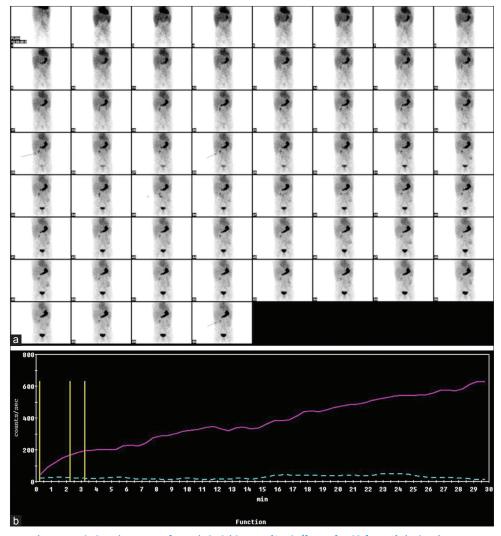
(a) Tc-99m pertechnetate scintigraphy was performed. Serial images (1 min/frame for 60 frames) depicted tracer accumulation in the right hypochondrium (multiple arrows) along with tracer uptake in the stomach. (b) Tim-activity curve (a) of the stomach (pink curve) depicts a rising curve. Time-activity curve of the lesion in the left hypochondrium and lumbar region (green curve) shows a flat curve as the activity gradually increased in intensity in delayed images only
